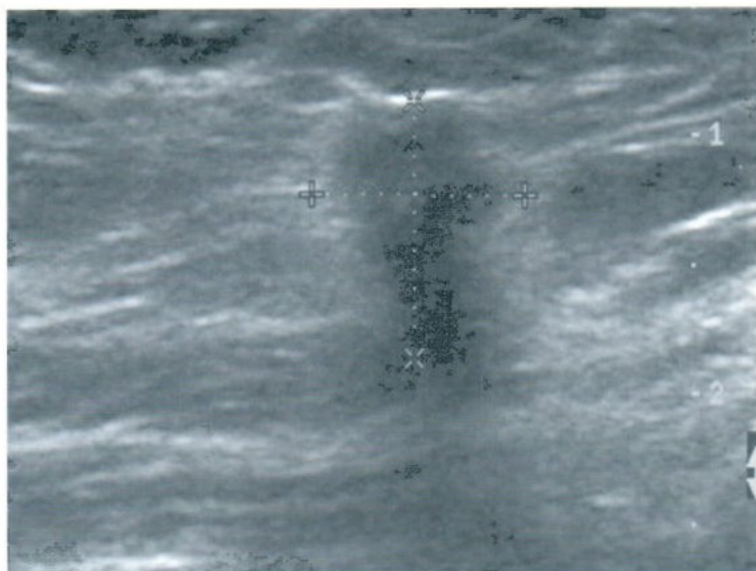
Ultrasonography of left breast mass showed Irregular shape, angular margin, taller than wide mass with thick echogenic rim and posterior shadowing.
